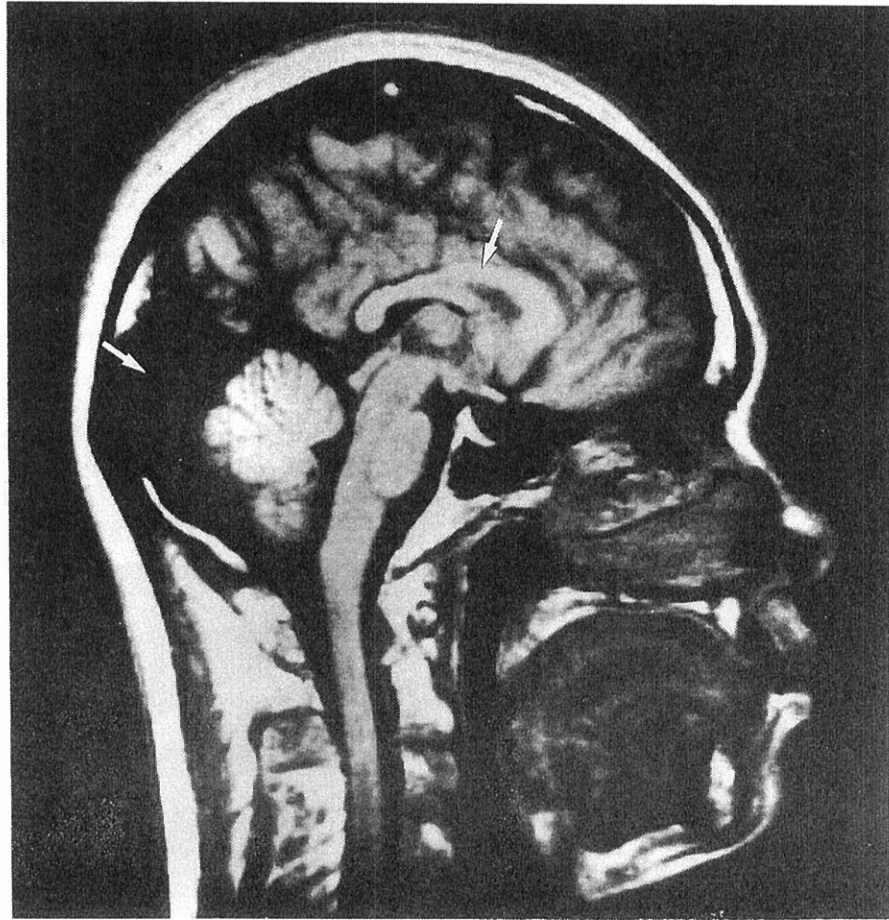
A 5-mm-thick sagittal T1-weighted spin-echo image. The scan parameters were TR = 400 ms and TE = 25 ms. Observe the compressed nature of the cerebellum and the large cavernous space to its posterior. Note too the corpus callosum. (Case 4)
